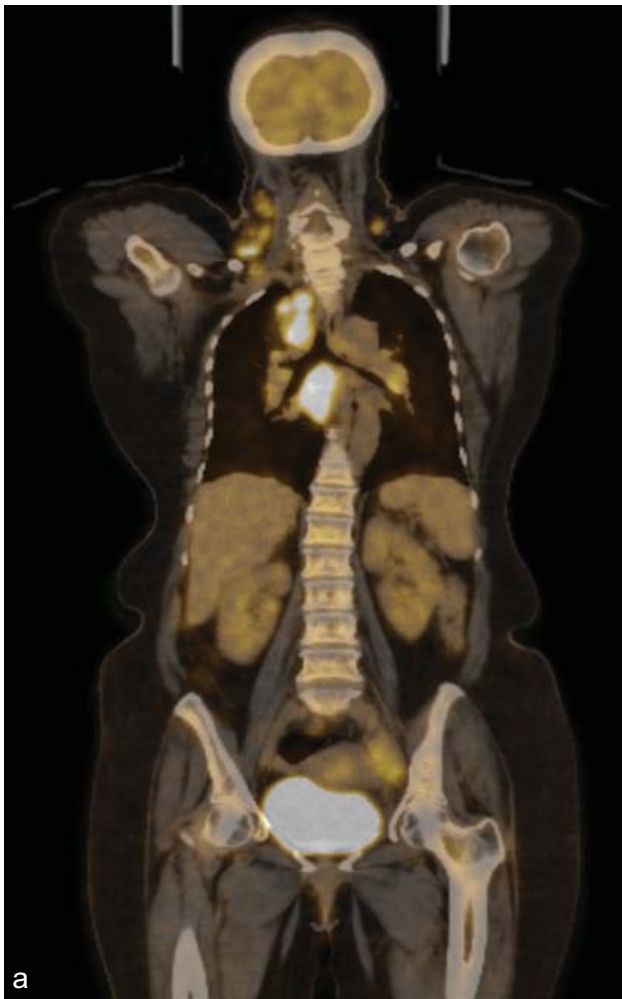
Coronal image of PET CT showing hyper-metabolic neck and mediastinal nodes
